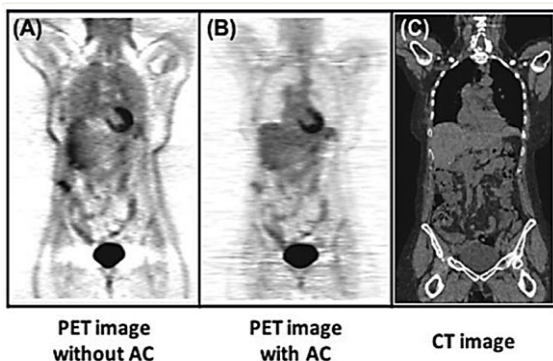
Photon Attenuation Must Be Corrected for Accurate PET Imaging. A) PET Image Displaying Several Artefacts Without Attenuation Correction; B) CT Attenuation Correction in A PET Image; C) Corresponding CT Image.
